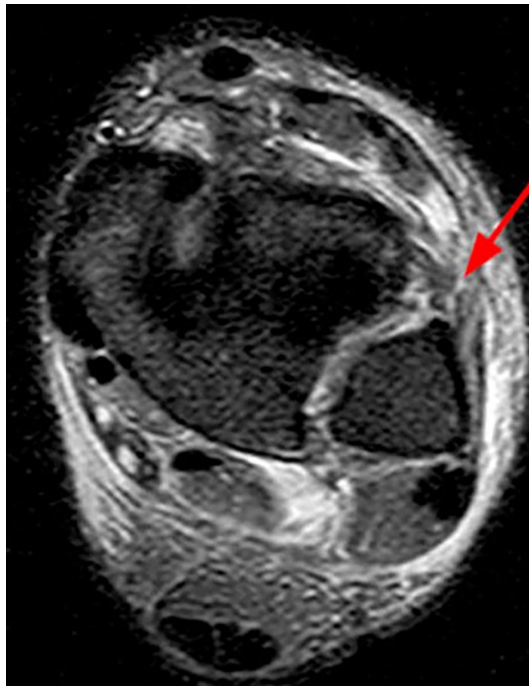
MRI imaging Shows an AiTFL rupture in the T2-weighted axial plane
